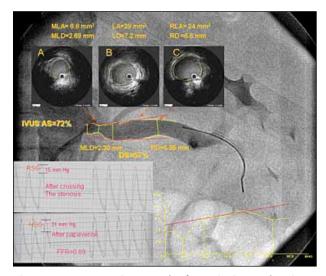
A representative example of quantitative renal angiography, IVUS analysis, and translesional pressure gradient is shown in one study patient with RAS. The minimum lumen diameter and minimum lumen area from the stenotic segment (A) as well as the reference diameter and reference lumen area from the reference segment (B) were selected for both quantitative angiographic and IVUS analyses. Panel C shows the segment with poststenotic dilation. Quantitative renal angiography demonstrates that the diameter stenosis of the renal artery is 57%, not significant by CORAL Study Criteria. IVUS area stenosis and HSG are 72% and 31 mm Hg, respectively; both are indicative of significant RAS. Reprinted from Journal of the American College of Cardiology, 53/25, Massoud A, et al. Prediction of hypertension improvement after stenting of renal artery stenosis: comparative accuracy of translesional pressure gradients, intravascular ultrasound, and angiography, 2363-2387, 2009, with permission from Elsevier. 12
